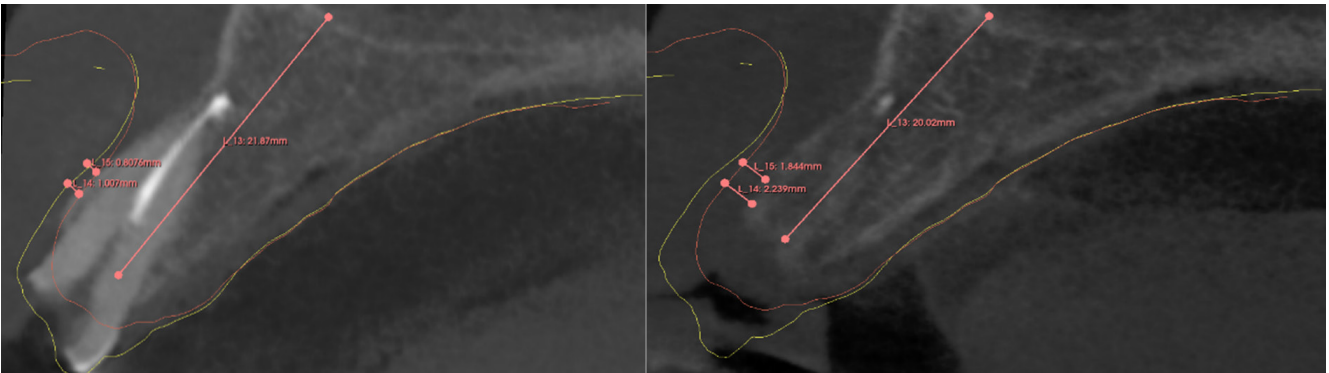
Facial soft tissue thickness measurements of the pre and postoperative CBCTs using 3D slicer
